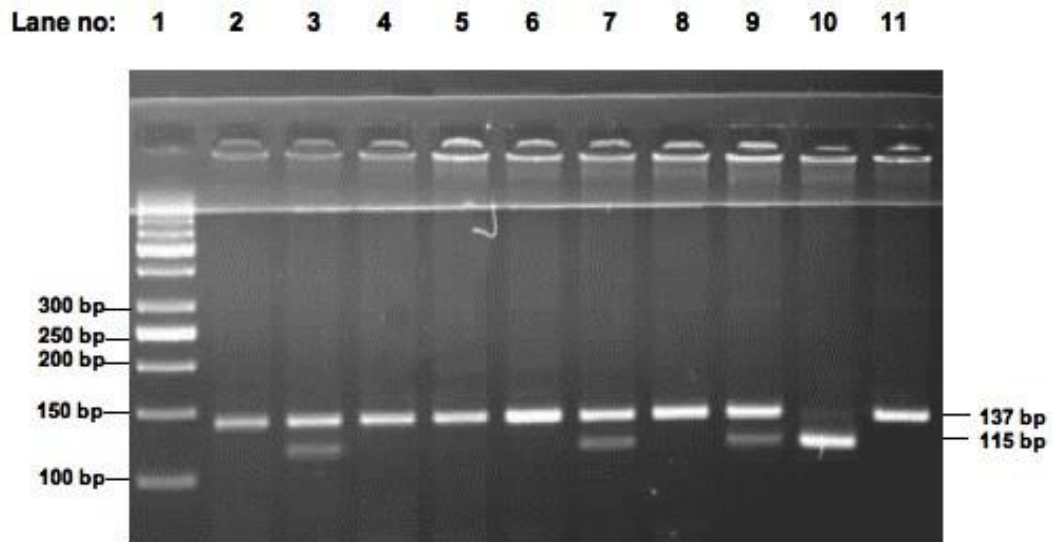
12 3% Nu-micropore agarose gel electrophoresis of *Hpa* I digestion products for rs944688 SNP region of GABA_{B2}. First lane was loaded with DNA ladder (50-1000 bp), following lanes were loaded with digestion products of the subjects. Lane 2, 4, 5, 6, 8 and 11 show wild type genotype (CC) with 137-bp band. Lane 3, 7 and 9 show heterozygous genotype (CT) with 137-bp and 115-bp bands. Lane 10 shows polymorphic genotype (TT) with 115-bp band. (50-bp band, at the bottom of the gel, is an indicator of primer dimer).
